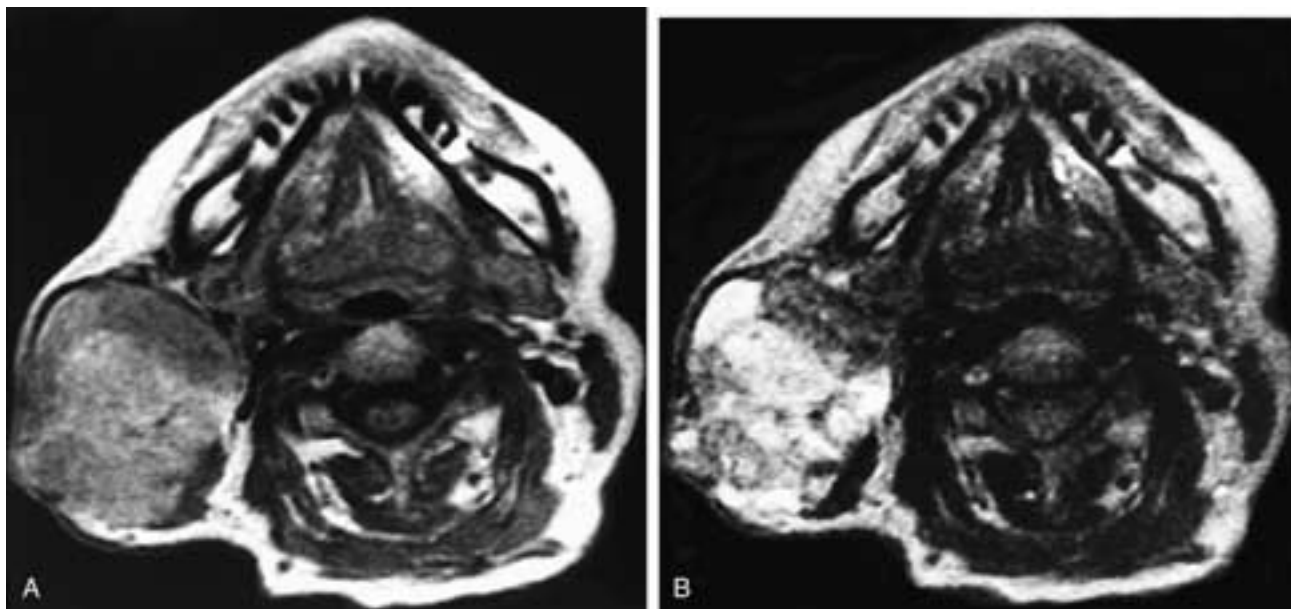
Axial T1-weighted (A) and T2-weighted (B) MR images show a large right nonhomogeneous parotid mass with well-defined margins except laterally, where the tumor has broken through to the skin. This patient had a carcinoma ex pleomorphic adenoma. With the exception of the focal tumor invasion of the skin, this imaging appearance suggests a pleomorphic adenoma.
